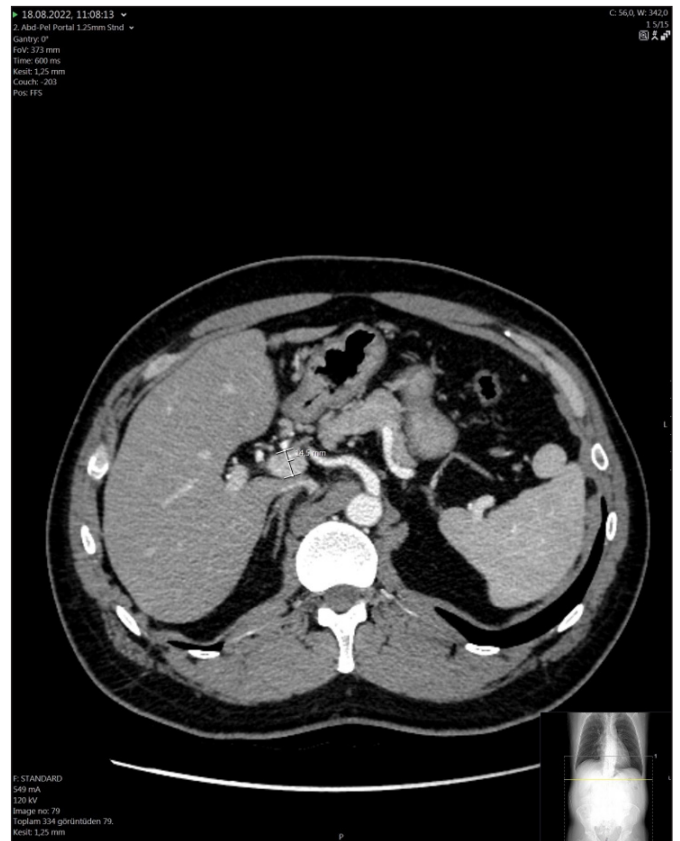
Measurement of portal vein diameter at the level of the liver hilum in axial multidetector computed tomography
